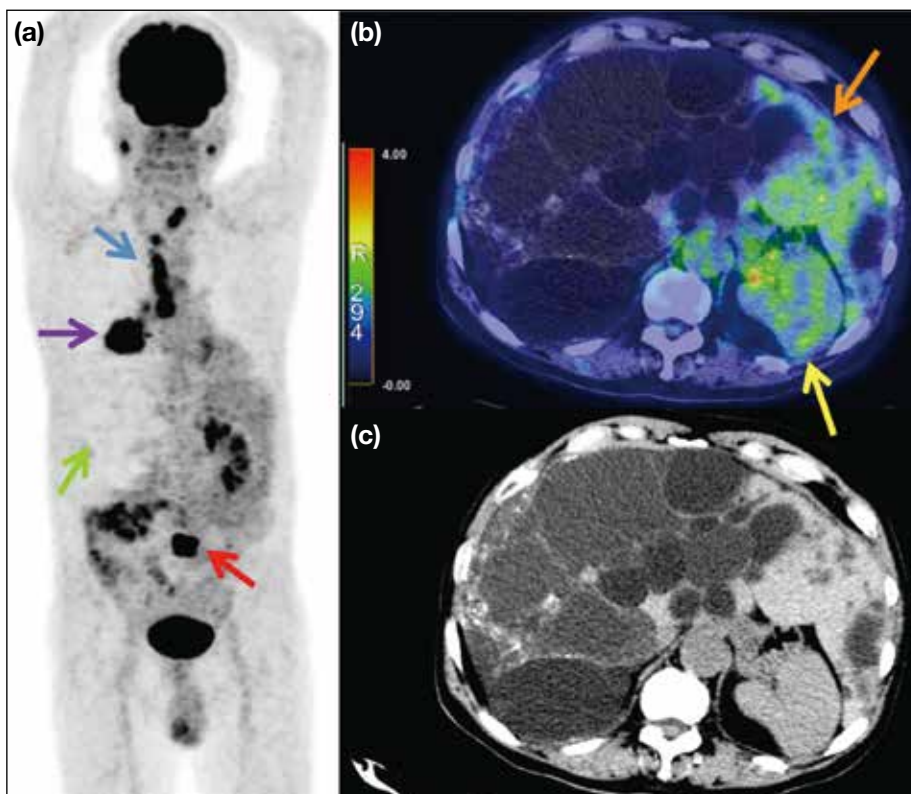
(a) Maximum intensity projection (MIP), (b) ¹⁸F-fluorodeoxyglucose positron emission tomography/computed tomography, and (c) computed tomography images of a patient suffering from polycystic liver disease. The right hepatic region in MIP has no uptake (green arrow in [a]) because of numerous large liver cysts, with a corresponding standardised uptake value ratio of 0.12. The left hepatic lobe (orange arrow in [b]) has uptake similar to that of the spleen (yellow arrow in [b]) because of smaller and fewer cysts compared to the right lobe. A hypermetabolic right lung tumour (purple arrow in [a]) with metastases to lymph nodes (blue arrow in [a]) and the L5 level (red arrow in [a]) are seen.
